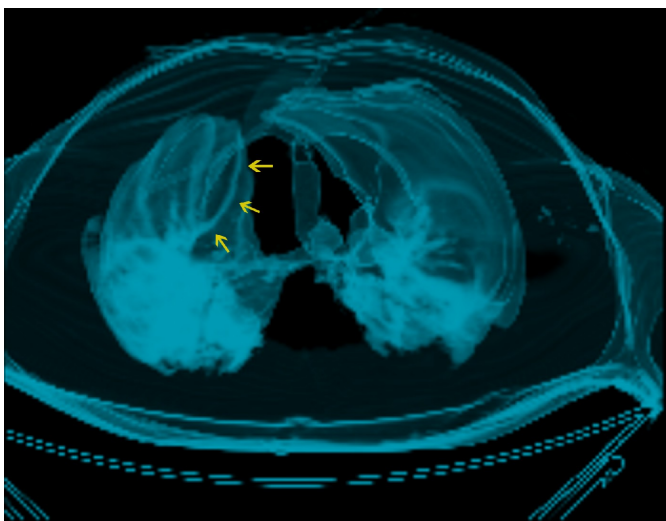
3D CT reconstruction of the lung parenchyma with the suspected route of penetration of the nasogastric tube.
